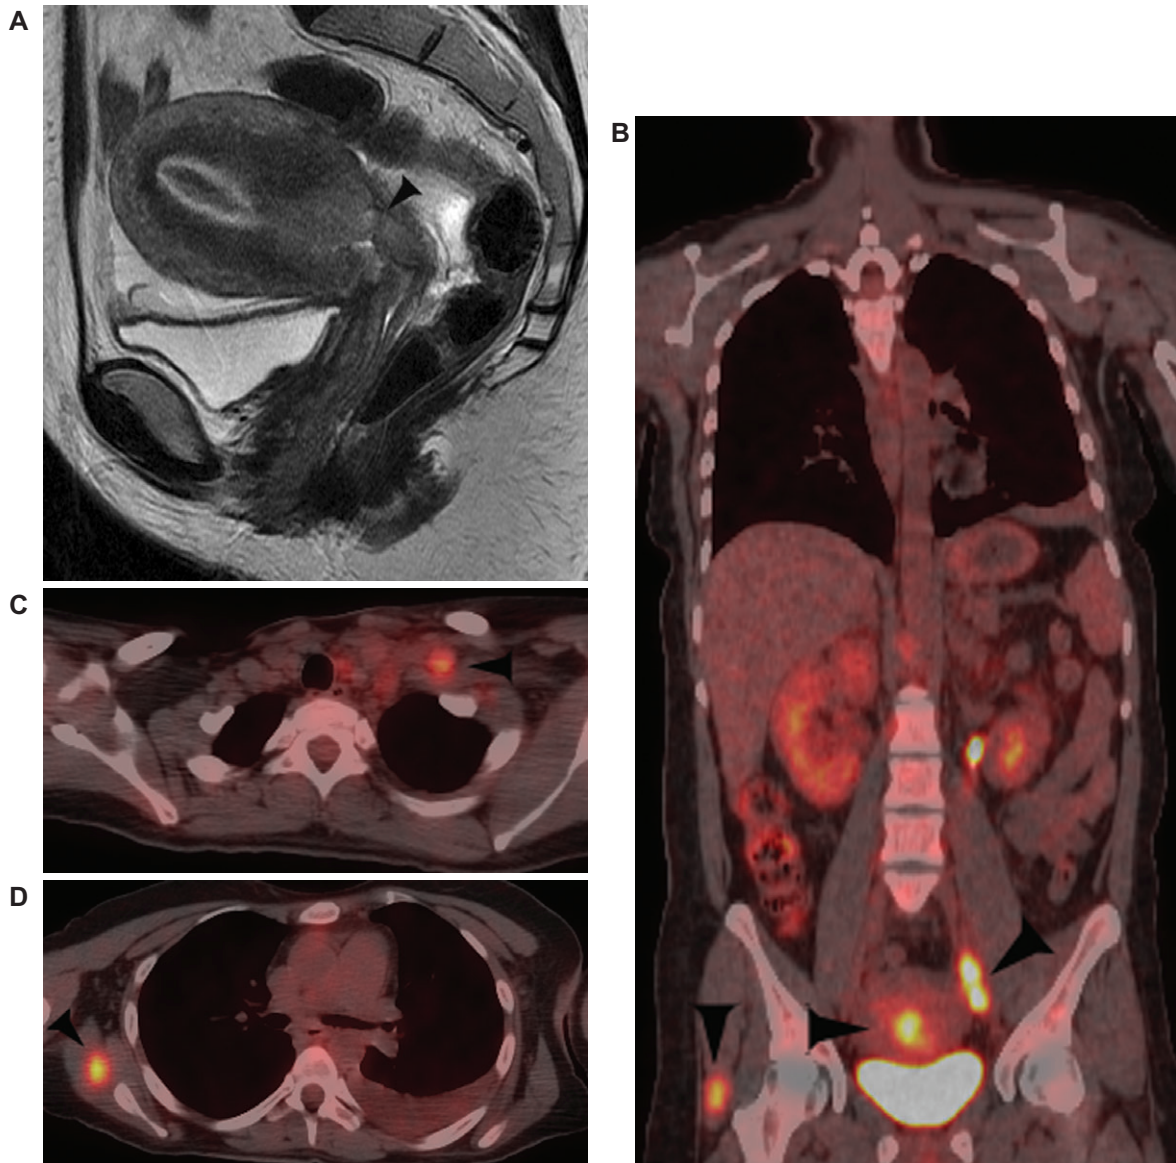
A 37-year-old female with newly diagnosed squamous cell carcinoma of the cervix. (a) Sagittal T2-weighted MRI of the pelvis shows cervical tumor (arrowhead); (b) coronal fused PET/CT shows FDG avid primary tumor and adenopathy in the pelvis as well as uptake adjacent to the right hip (arrowheads), subsequently proven soft tissue metastasis; (c) axial fused PET/CT shows FDG avid adenopathy in the left supraclavicular fossa (arrowhead); (d) axial fused PET/CT also shows another FDG avid soft tissue metastasis in the right periscapular region (arrowhead).
